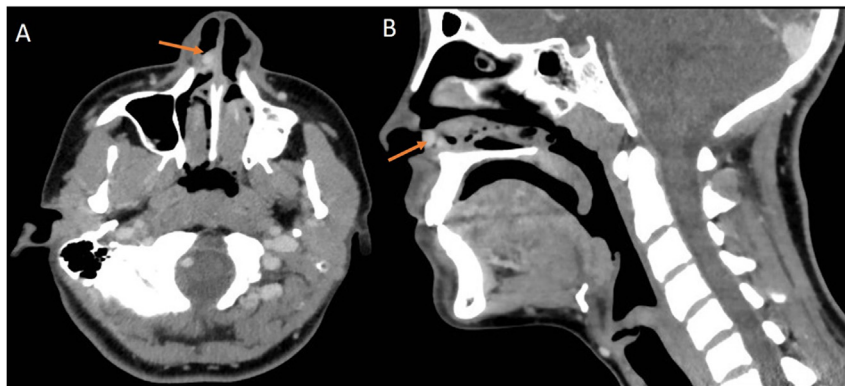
Case 2. Contrast enhanced computed tomography (CT). Axial (A) and sagittal (B) sections. Arrow = bilobed well defined mass arising from the anterior septum.
